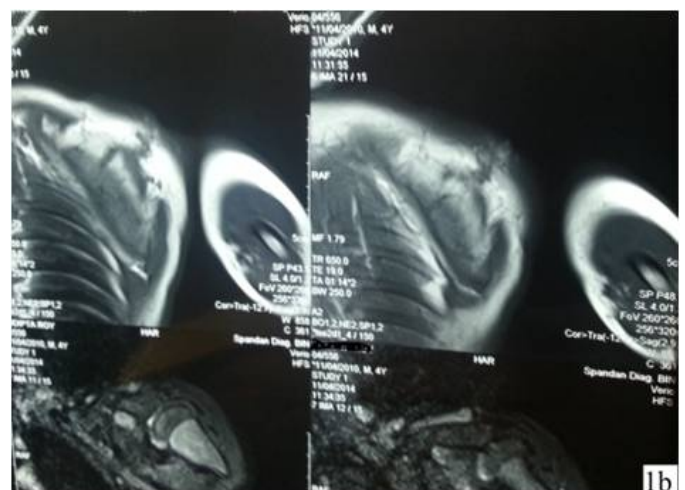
MRI of It shoulder region showing scapular lesion.
